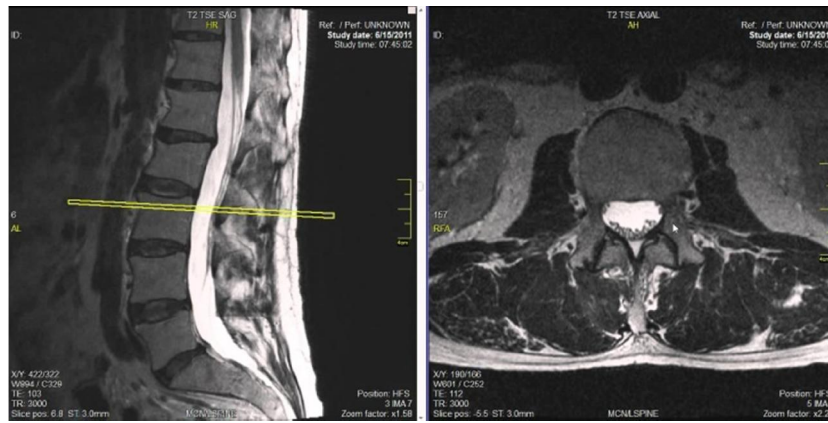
Lumbar spine MRI sagittal and axial views (www.radiopaedia.org)
